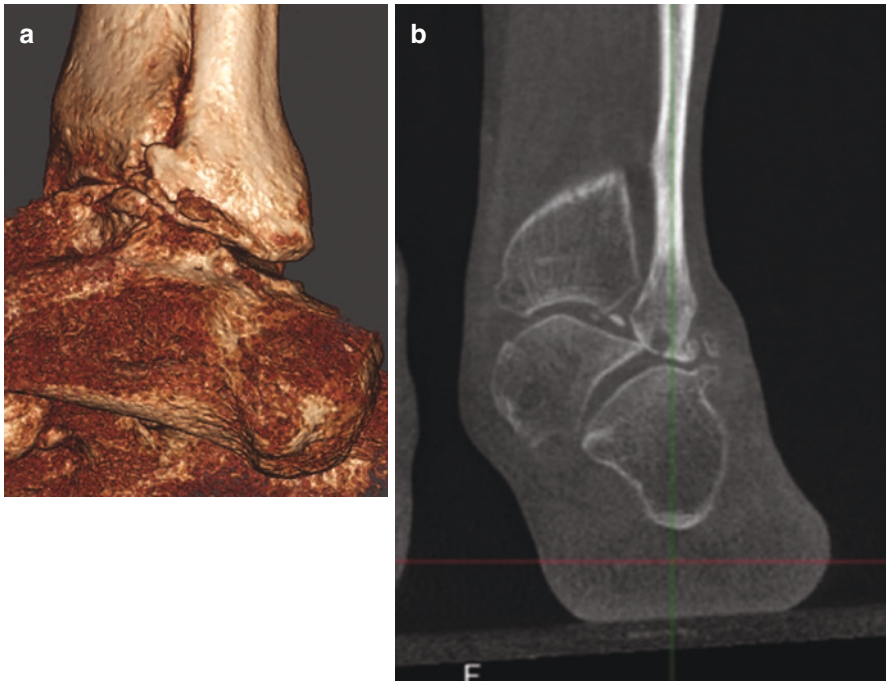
Is a classic case of subficular impingement. (a) shows the 3D rendering view on which the diagnosis is self-evident. We advocate for the use of the 3D rendering view to fulfill in the future the need for a “snapshot” view which before was provided by conventional radiographs. In the future, virtual reality and holographic projectors will probably provide for a comfortable and immediate interface valid for daily clinical use. (b, c) correspond to the coronal and sagittal views of the multiplanar windows. The TALAS (d) window in this case shows a major case of valgus, explaining this situation, with a close to 20% foot ankle offset. The FAO is given as a percentage of foot length, in order to be comparable across different patients. In this case, that means that the patient’s mass is distributed with an offset so large that it is actually projected outside, on the medial side of the plantar surface. In physical terms, this means the foot tilts on each step, explaining the major subficular impingement
